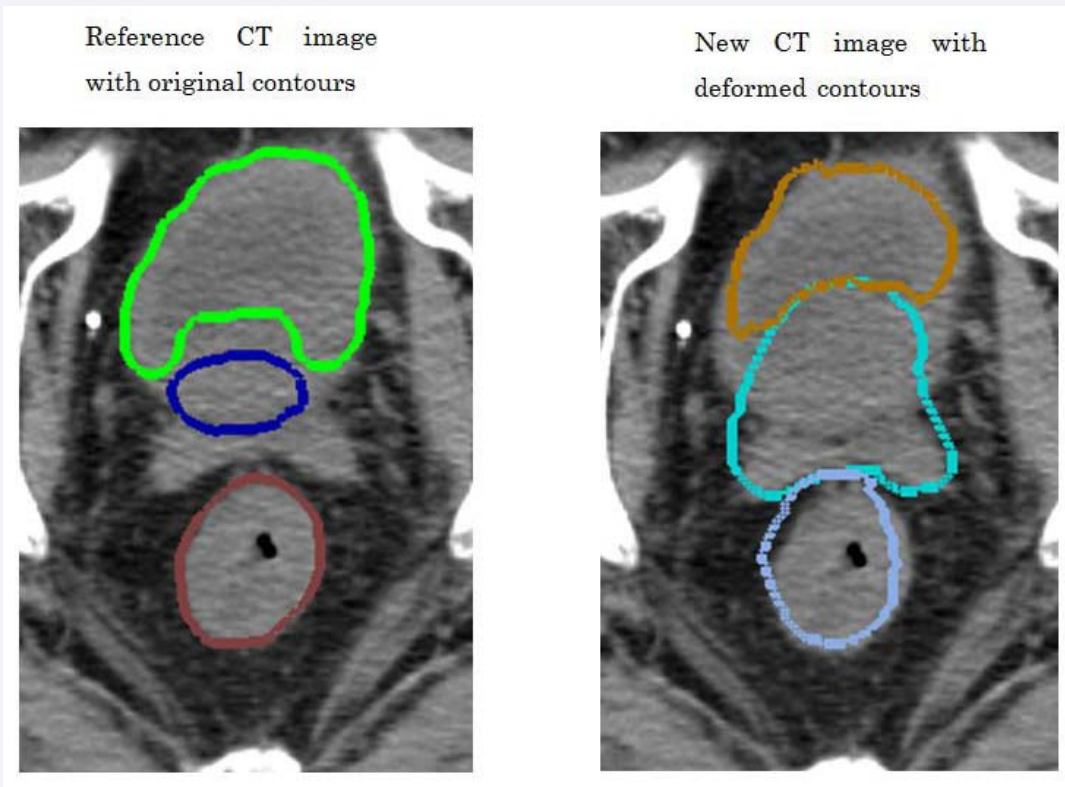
Example of auto segmentation by deformable image registration for prostate cancer patient. The left figure showed the reference CT image with original contours. The right figure showed the new CT image with deformed contours.
